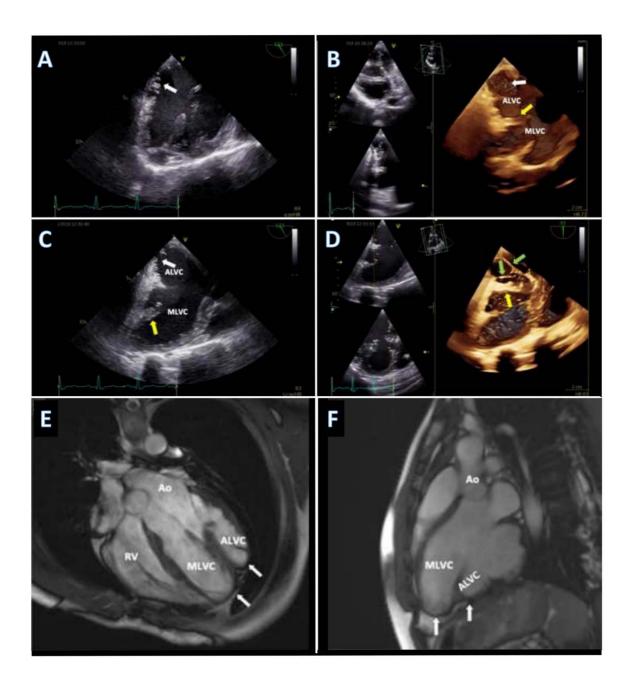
Transesophageal echocardiography demonstrates the ALVC and MLVC separated by a muscular band (B, C, D; yellow arrows), with the ALVC exhibiting hypertrabeculation (A, B, C; white arrows) and two pseudo-chords (D; green arrows). Cardiac magnetic resonance reveals an irregularly shaped LV with a double apex (E, F; white arrows)
